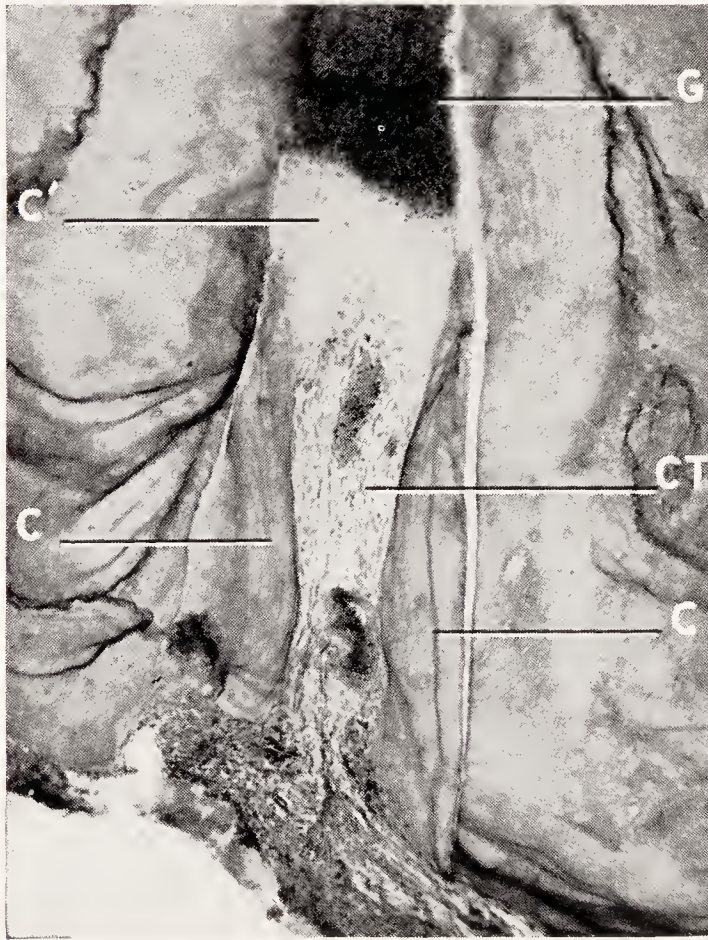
Cementum deposition in the apical portion of the root canal several years after pulp removal and root canal filling. *G*, guttapercha; *C*, cementum covering the wall of the apical portion of the root canal; *C'* cementoid (newly formed uncalcified cementum) deposited upon the guttapercha; *CT*, connective tissue in the root canal.
